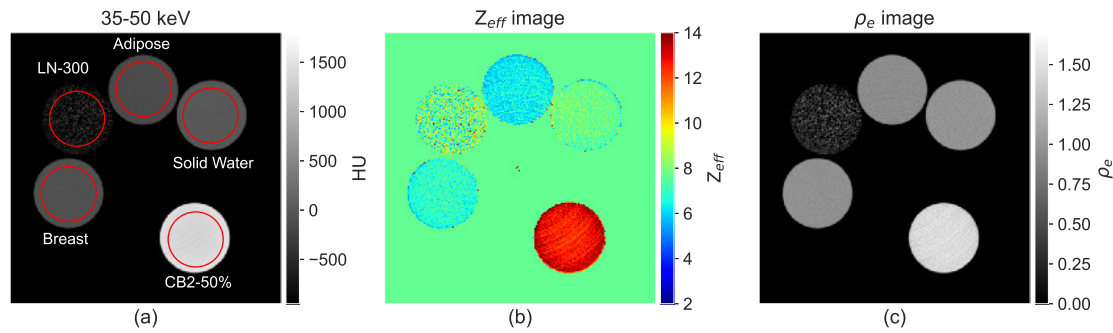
PCD-CT images of the second evaluation subset of tissue equivalent materials and water. (a) 35-50 keV CT image with labeled materials and ROIs depicted in red. (b) Effective atomic number image. (c) Relative electron density image.
